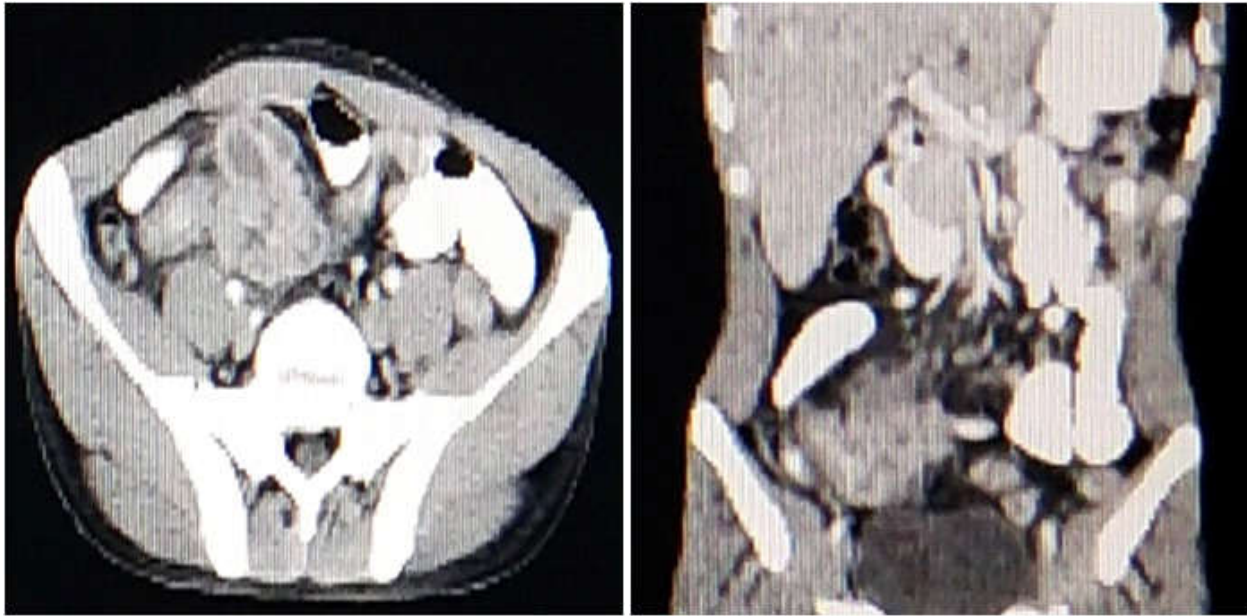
Computed tomography abdomen showing edematous and thickened bowel loops in right iliac fossa suggestive of ileal inflammatory mass with collection
